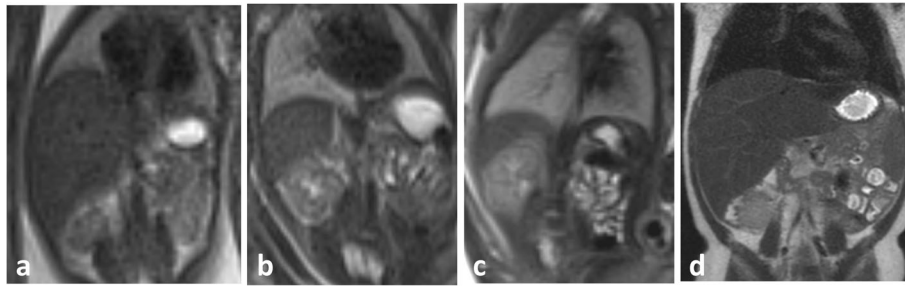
Selected images of coronal T2-weighted MRI showing the appearance of normal diaphragm (arrows) at 21, 29, and 33 weeks of gestation and in a newborn (a, b, c and d respectively)
